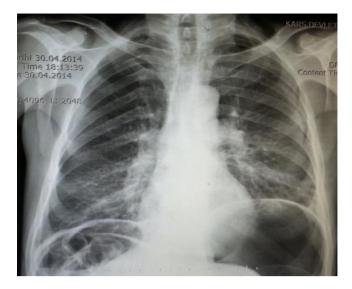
X-ray free air under the diaphragm.
